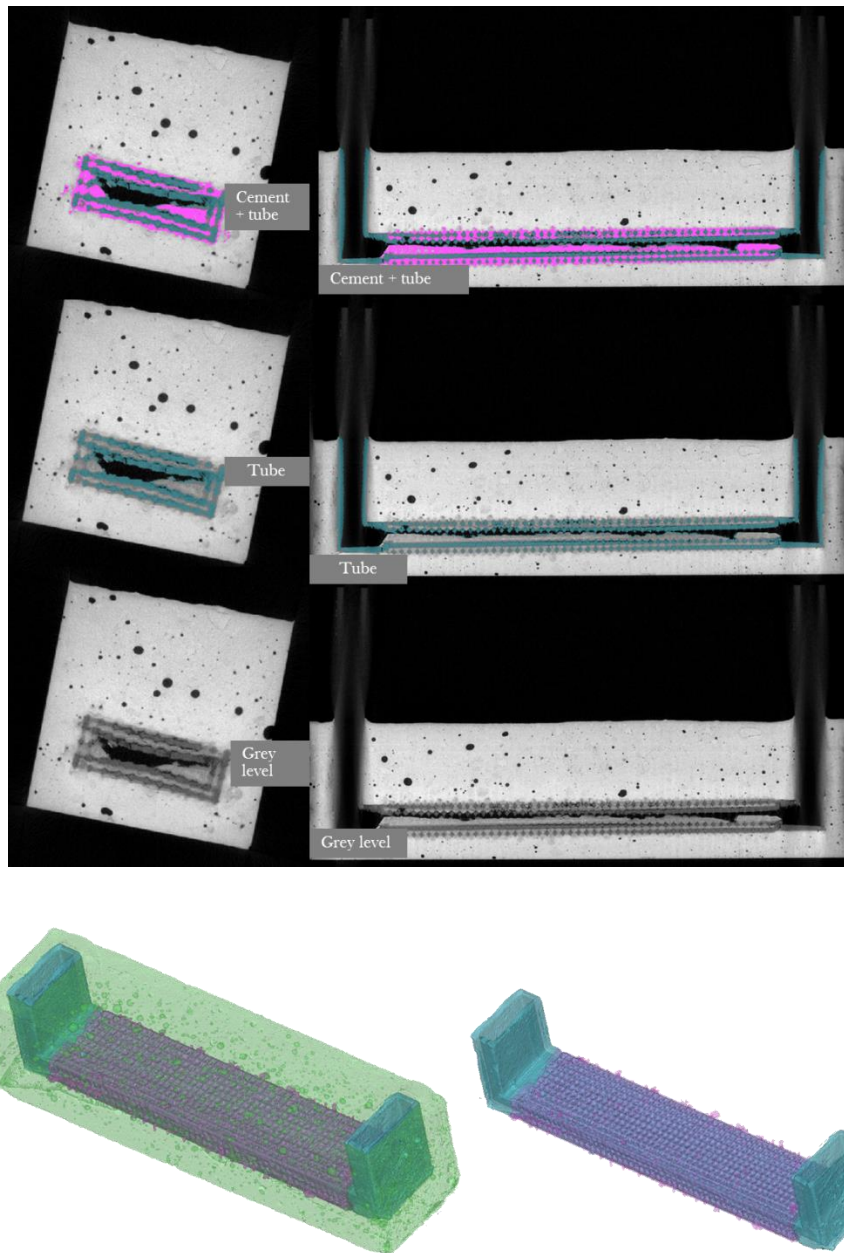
CT gray level images of cement matrix incorporating with plate shaped model, where the fluorescent pink coloured part represents cement penetrate to the model; cyan coloured part represents PLA structure; reconstructed images were presented at the bottom, same colour code was applied to the reconstructed image, with green colour added representing cement bulk
